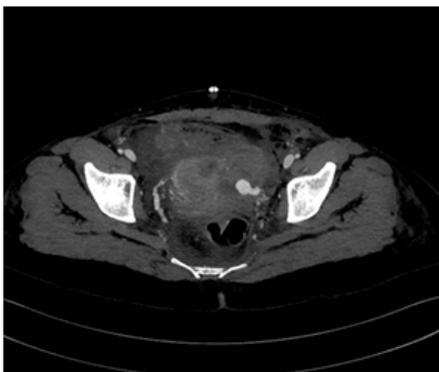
CT scanning reveals pseudo aneurysm and active bleeding from left uterine artery after caesarian section. Patient continued to lose significant blood despite packing and re-look surgery. Hb fell significantly and patient was moribund. Angiography reveals a large active bleeding from left uterine artery embolised successfully with a micro coil. Patient had an uneventful recovery after embolisation.
